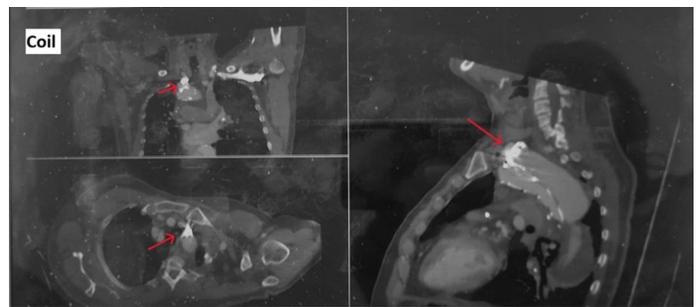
Red arrows pointing at Coil in Subclavian artery at CT angiography
